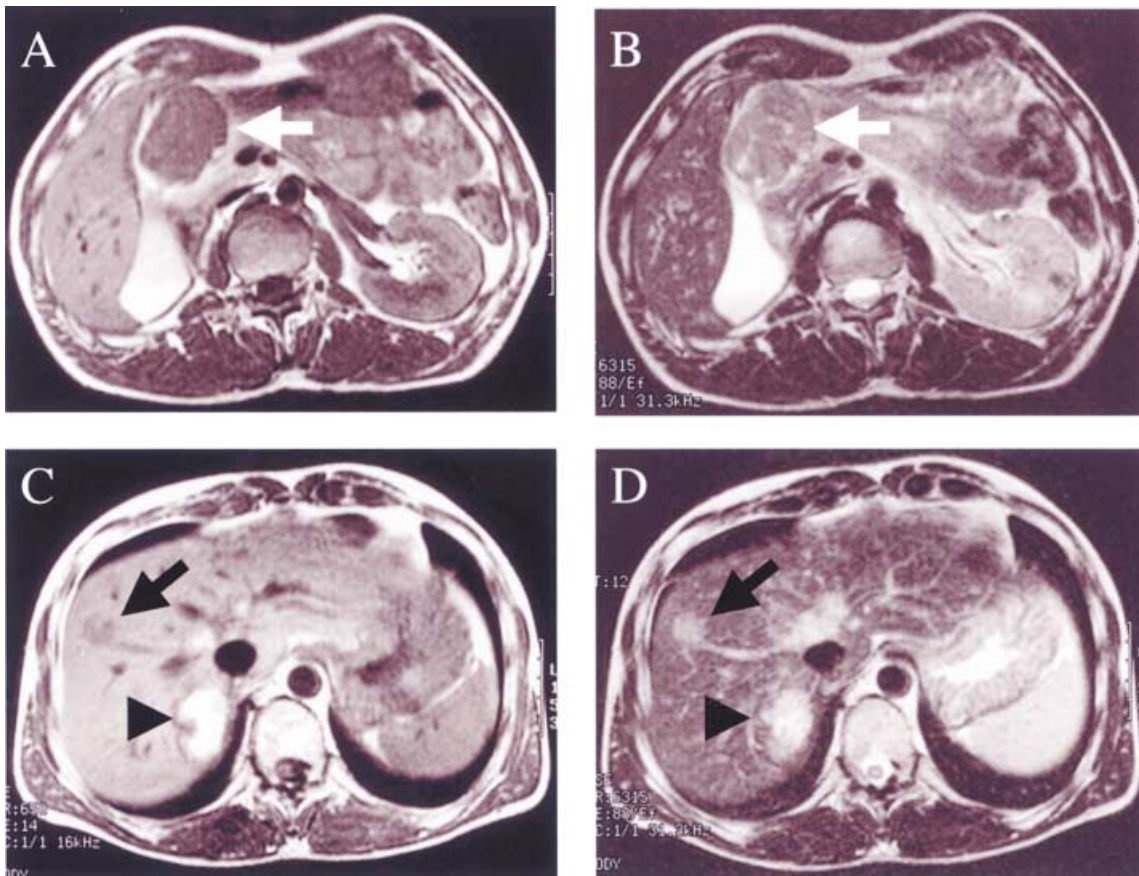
A-D. Magnetic Resonance Imaging (MRI) : The omental tumor (white arrow) is 5 cm in diameter, T1-weighted low-(A) and T2-weighted high-(B) intensity. C T1-weighted MRI of the liver demonstrates a well-defined and round tumor with a low signal intensity in Segment VIII (black arrow) and high signal intensity in Segment VII (black arrow head). D T2-weighted MRI of the same tumor demonstrates moderately high signal intensity.
